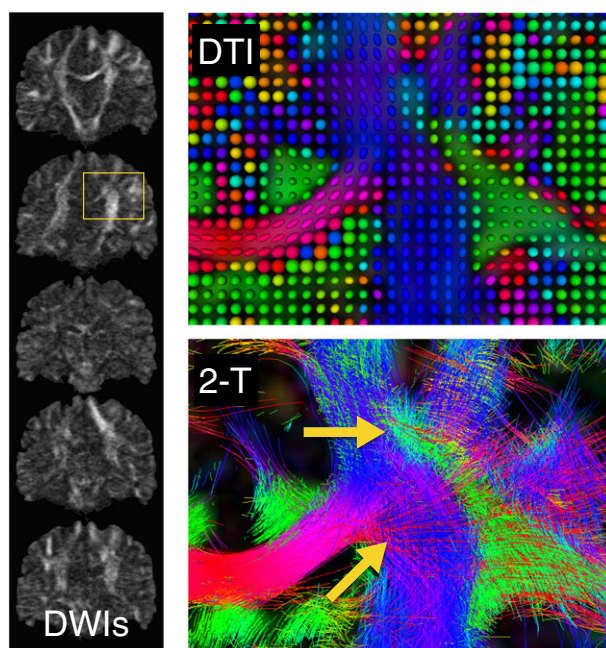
Computational methods for diffusion MRI are needed to analyze input diffusion-weighted image (DWI) data to enable visualization or quantitation. At the left, coronal images show DWIs acquired using several gradient directions. The yellow box indicates the zoomed region shown in the images at the right, which result from computational analysis of the DWIs. Colors encode fiber orientation such that left–right is red, inferior–superior is blue, and anterior–posterior is green. The traditional single diffusion tensor model (DTI, top right) is shown using ellipsoids for tensor visualization. DTI analysis has led to important findings, but it cannot represent anatomical fiber tract crossings (bottom right image, arrows), which can be seen with a multi-fiber model such as the two-tensor (2-T)^{10,11} tractography shown here. These images were created using the first dataset from the Human Connectome Project¹² using the SlicerDMRI package in 3D Slicer^{13,14}
